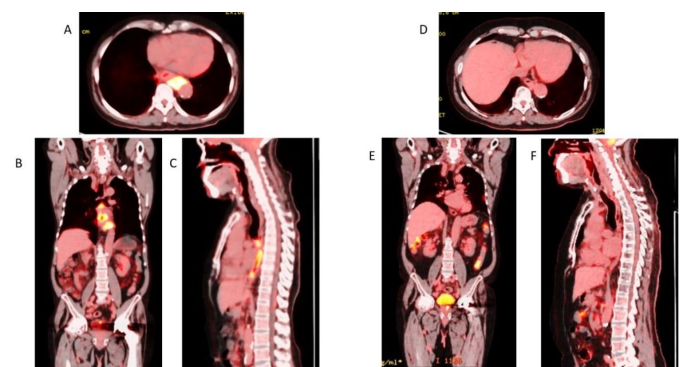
(Left- A-C) Pre-treatment and (D-F) Post-treatment PET CT images in axial, coronal, and sagittal planes showing complete resolution of esophageal cancer lesion.
